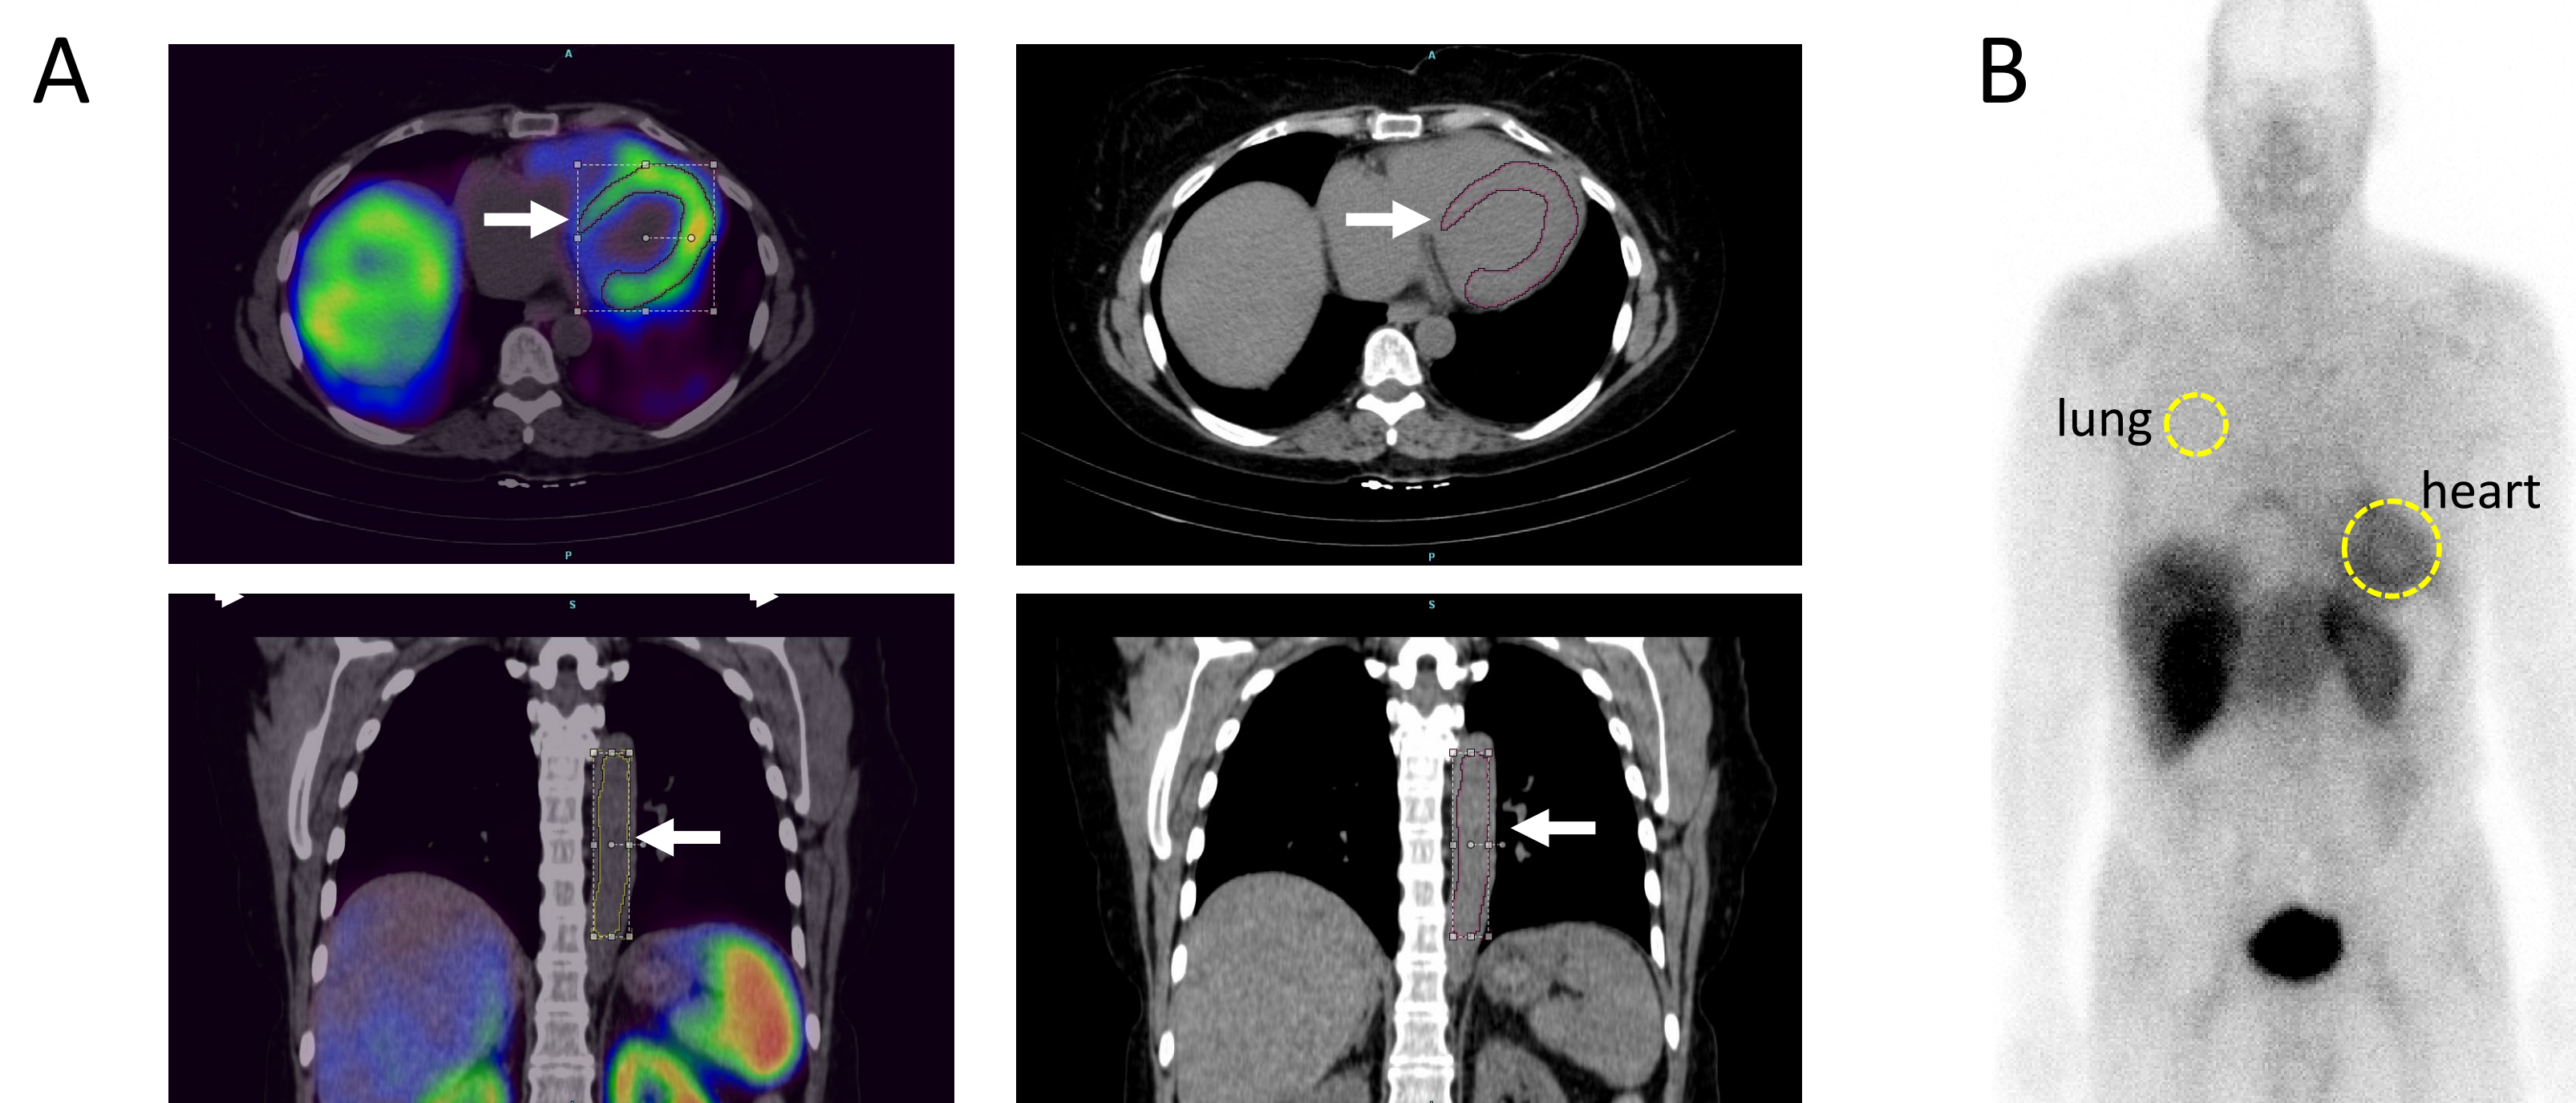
For semi-quantitative analyses, the uptake of ^{99m}Tc -p5+14 and ^{99m}Tc -PYP in the heart and blood (in SPECT/CT images) and heart and lung (in planar images) were assessed using manual 2D region of interest analysis of the images.
